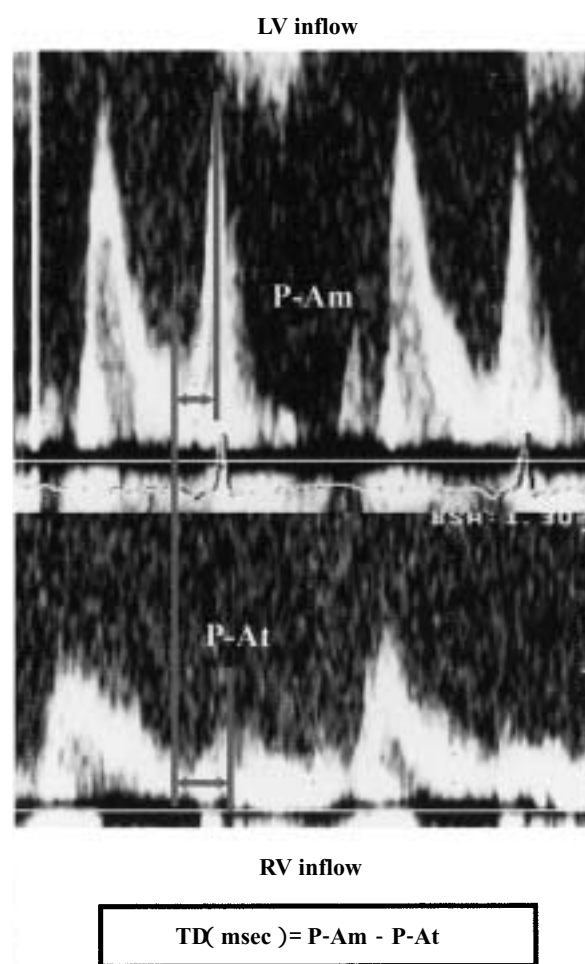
Doppler echocardiogram recorded just below the mitral (upper) and tricuspid valves (lower) in Case 10
